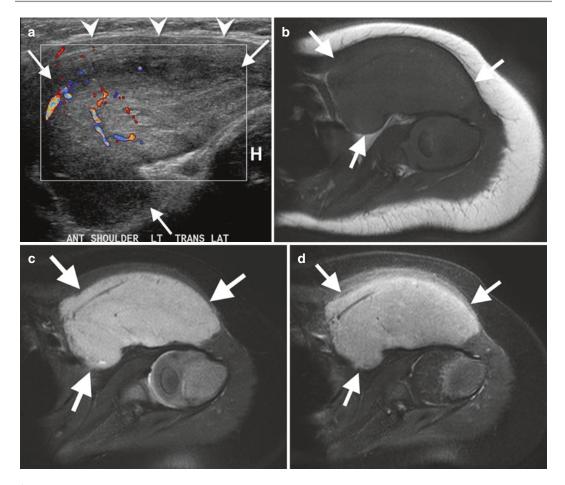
(a–d) Infantile fibrosarcoma (*arrows*) located anterior to the left shoulder of a 6-month-old girl. (a) The mass located deep to the pectoralis muscles (*arrowheads*) and anterior to the humoral head (H) is echogenic and shows vascularity on ultrasound. It is iso- to slightly
